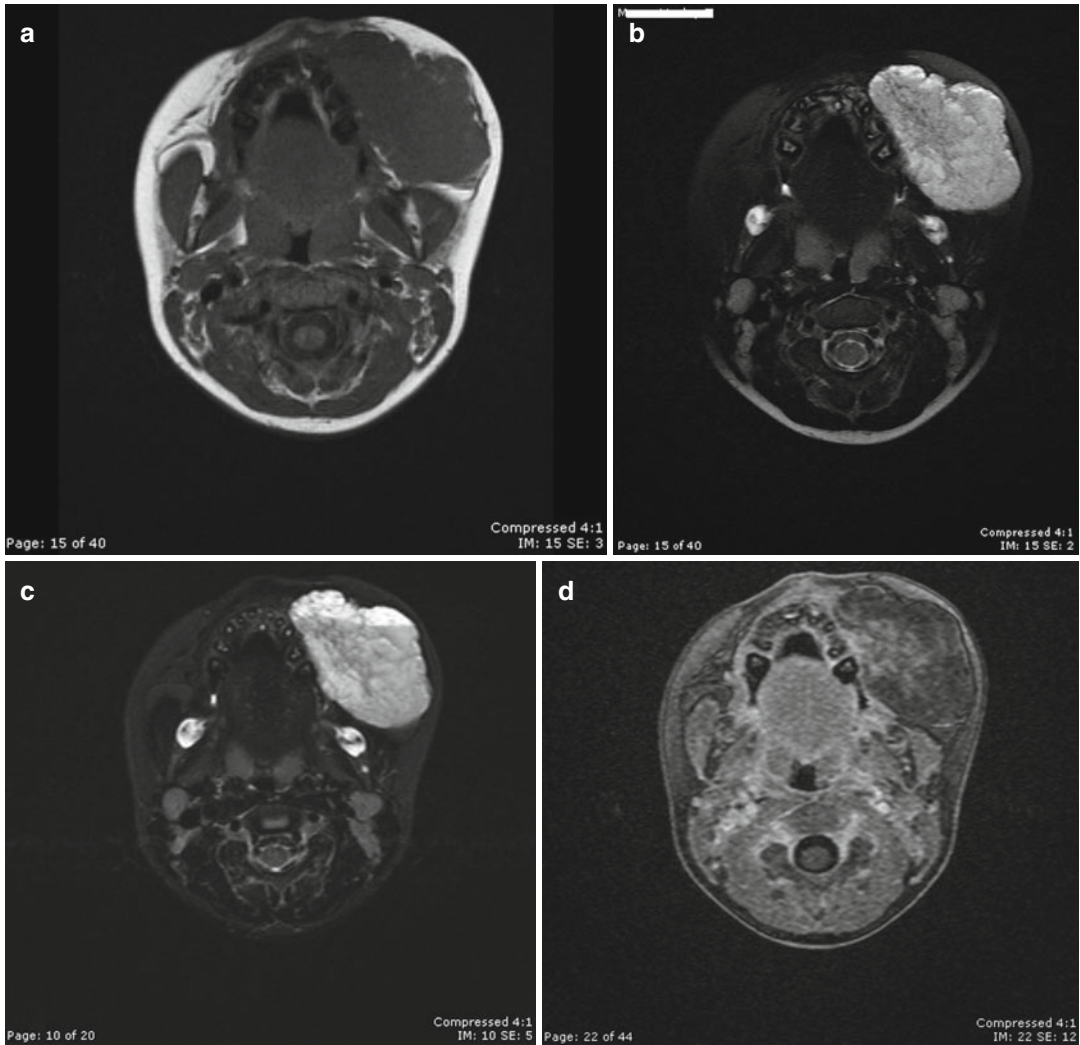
Five-year-old girl with cheek venous malformation. (a) Axial T1-weighted image shows an isodense lesion of the left cheek. (b) Axial fast SE T2-weighted fat-suppressed image demonstrates a well-defined hyperintense lesion without perilesional edema. (c) STIR
